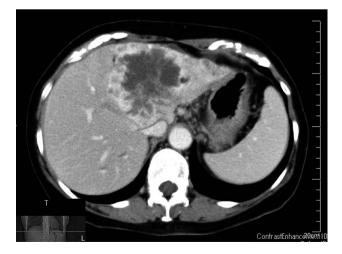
CT showed an irregular and peripherally enhancing mass in the left hepatic lobe.
